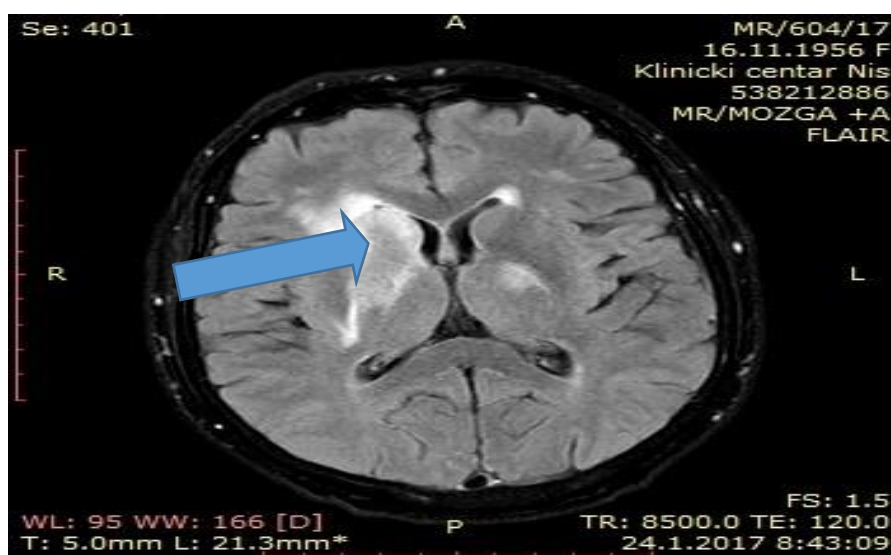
Axial Flair MR image showed multiple hyperintense lesions in the right basal ganglia
